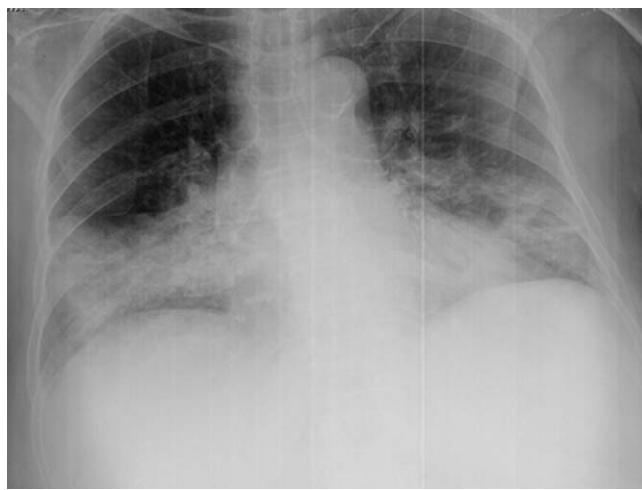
Chest radiography: alveolar consolidation in the right-middle and right-lower lobes and the lingula.
